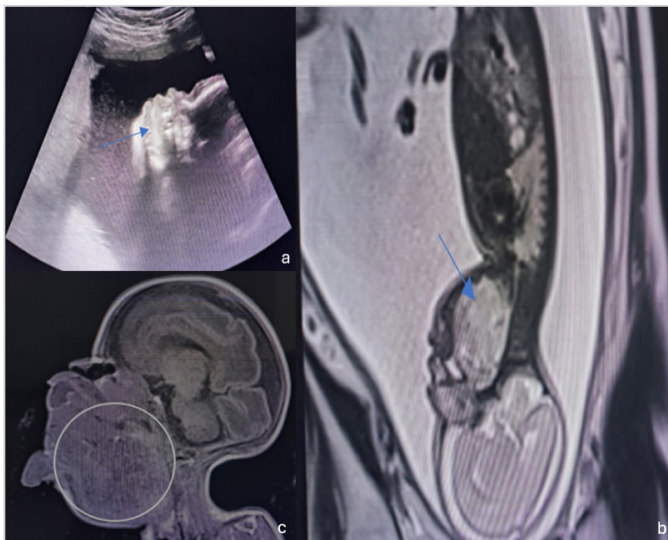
Prenatal and postnatal imaging showing a fetal oropharyngeal mass detected by ultrasound and magnetic resonance imaging (MRI) before birth and confirmed by computed tomography (CT) on postnatal day 2. a) Ultrasound image obtained 30 days prior to cesarean section showing a hyperdense mass in the fetal oropharynx. b) Fetal MRI obtained 25 days prior to cesarean section showing a heterogeneous mass measuring approximately 5×5 cm located in the oropharynx. c) Sagittal CT image of the fetus obtained on postnatal day 2 following cesarean section
